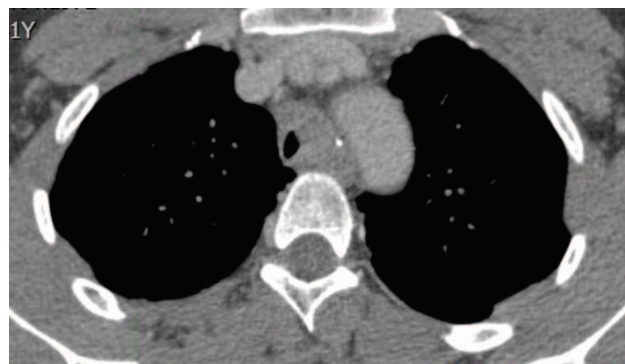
Computed tomography showing a mass on the left tracheal wall with intraluminal propagation.
